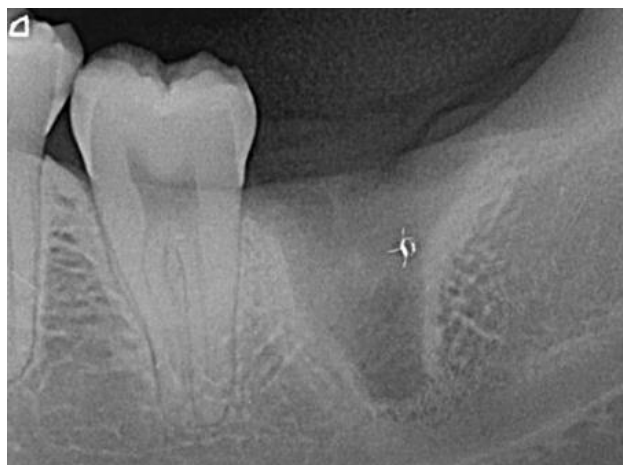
Patient's panoramic radiography.
